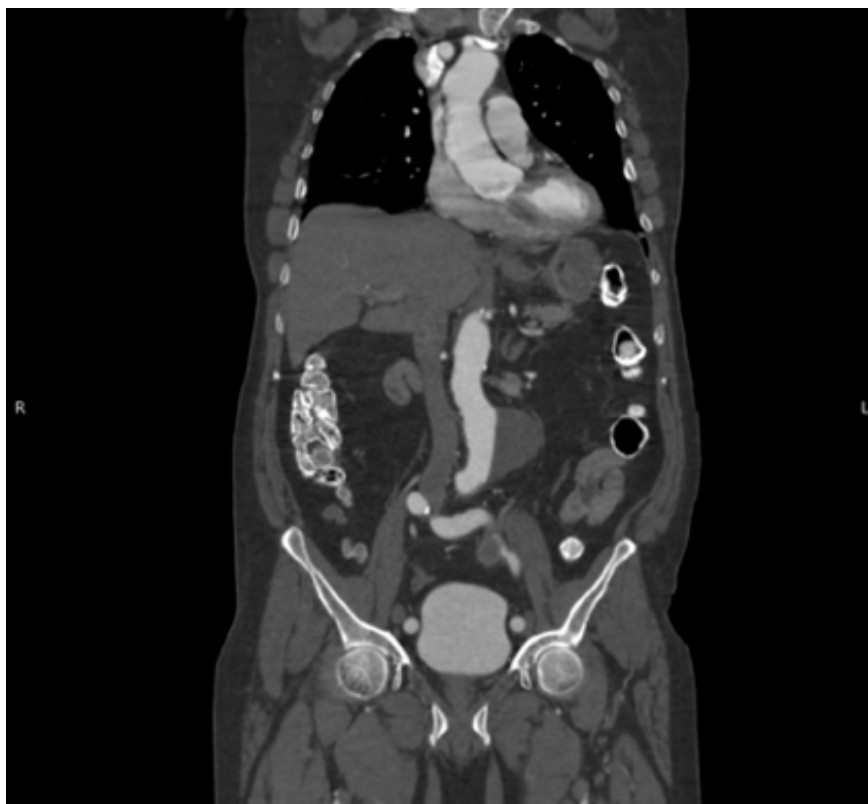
A computed tomography angiogram of the chest, abdomen, and pelvis revealed a 6.2-cm infrarenal abdominal aortic aneurysm with a mural thrombus with no evidence of rupture.
